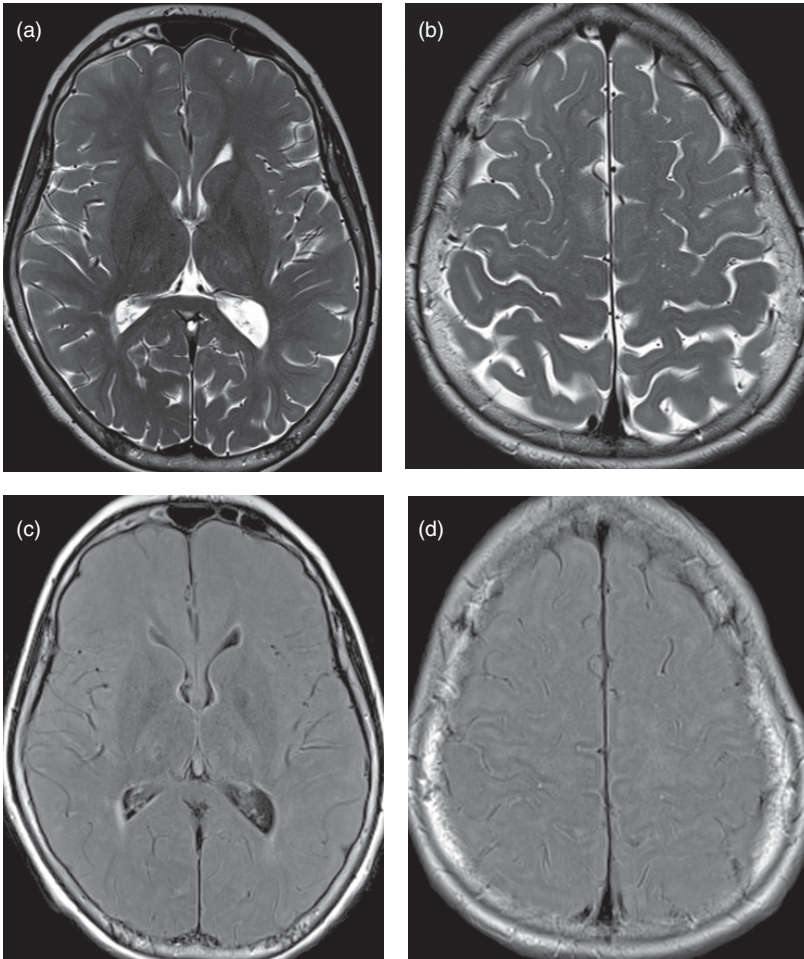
12-year-old female with classic galactosemia, severe tremor, and premature ovarian failure. Axial T2 images at the level of (a) the basal ganglia and (b) superior frontoparietal lobes demonstrate somewhat attenuated grey-white matter differentiation. (c, d) On same level FLAIR images, there is a patchy high signal, suggestive of hypomyelination.
